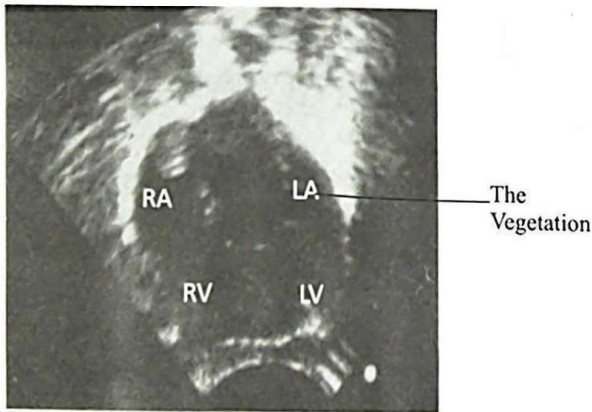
Echocardiographic findings of an atrial vegetation
